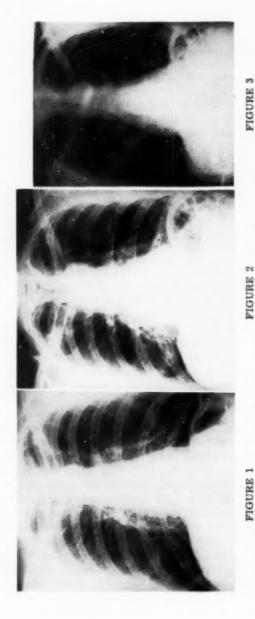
Routine chest x-ray taken June 7, considered normal.—Figure 2: Same patient on July 7, one hour after the sudden onset of chest pain and dyspnea. Note the widened mediastinum, prominent right pulmonary vessels and elevated left diaphragm.-Figure 3: Forty-eight hours later. Note the indistinct, hazy, round opacity in the left costo-phrenic sulcus.
